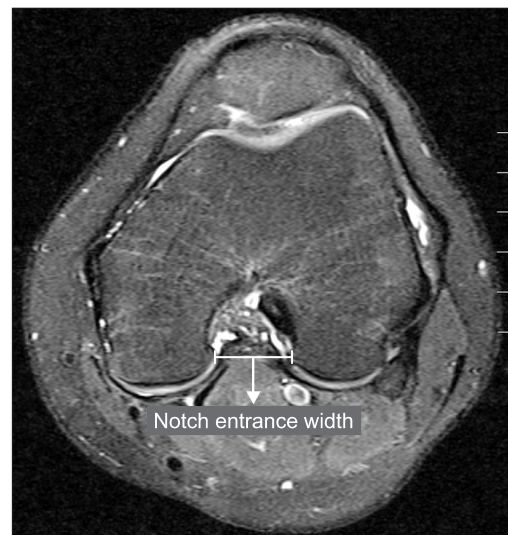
T2 axial view of knee magnetic resonance imaging. The notch entrance width was measured at each slice containing the notch, from the first slice with cartilage on both condyles to the last slice with bony connection between the medial and the lateral condyle.
